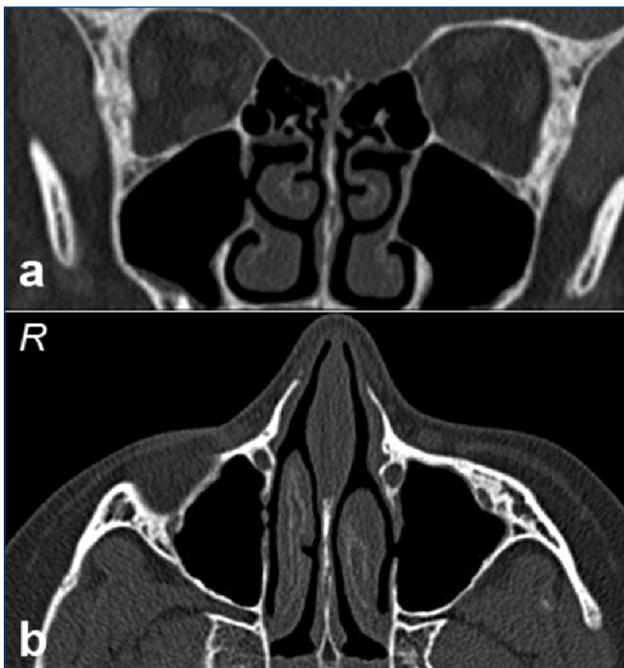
Paranasal CT sections of a 13-year-old boy with bilateral paradoxical middle turbinate and accessory maxillary ostium. a) coronal section b) axial section
